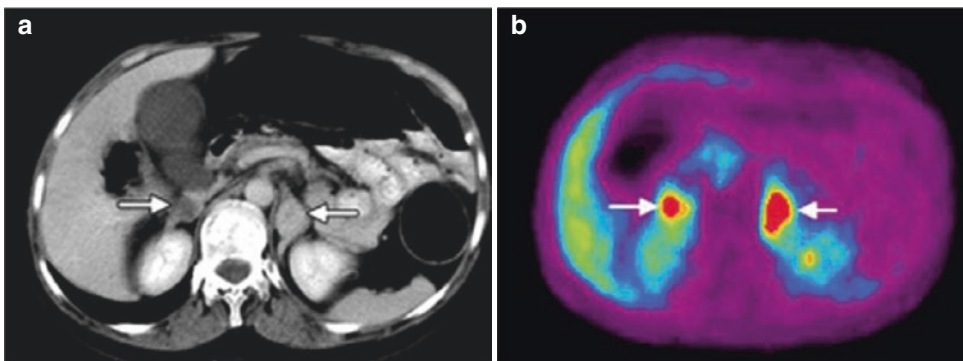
(a, b) Transverse images obtained in a patient with multiple endocrine neoplasia type 2 and an increase in urinary catecholamine levels. A CT image shows bilateral adrenal tumors (*arrows*) and a 2-cm-diameter tumor on the right side and a 4-cm-diameter tumor on the left
